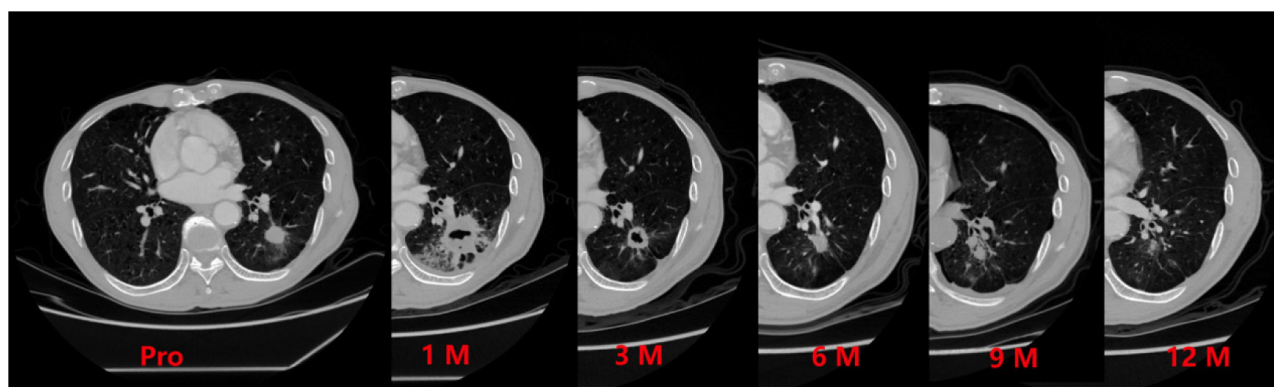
Primary non-small cell lung cancer (NSCLC) located in the left lower lobe. The 1-month computed tomography (CT) scan showed a large area of cavitation, and the size of the ablated lesion in the 3-month was larger than that before ablation. The 6-, 9-, and 12-month CT images demonstrated the progressive reduction in size of the ablated lesion (M: month).
